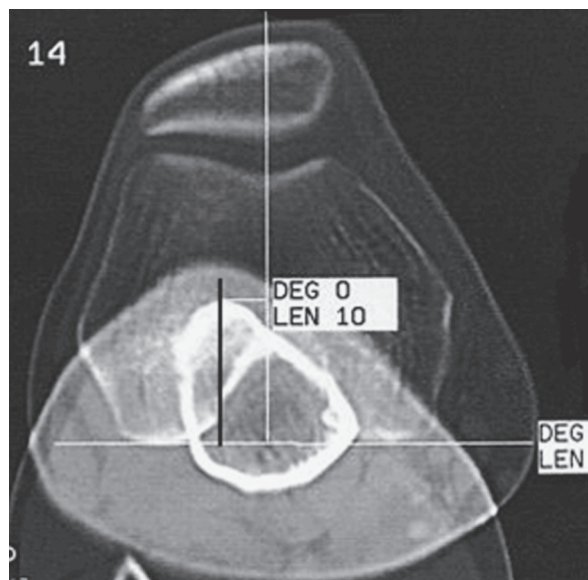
CT scan shows measurement of the distance TT-TG. Tibial Tubercle- Trochlear Groove is seen with overlay of distal femur and tibia at the level of tibial tuberosity. Also note trochlear shape, patellar shift, patellar tilt, patellar and trochlear subchondral bone sclerosis
